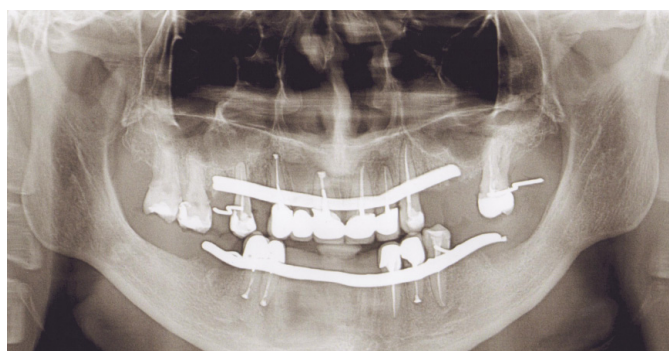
The orthopantomogram of the same patient 3 months after the replantation
